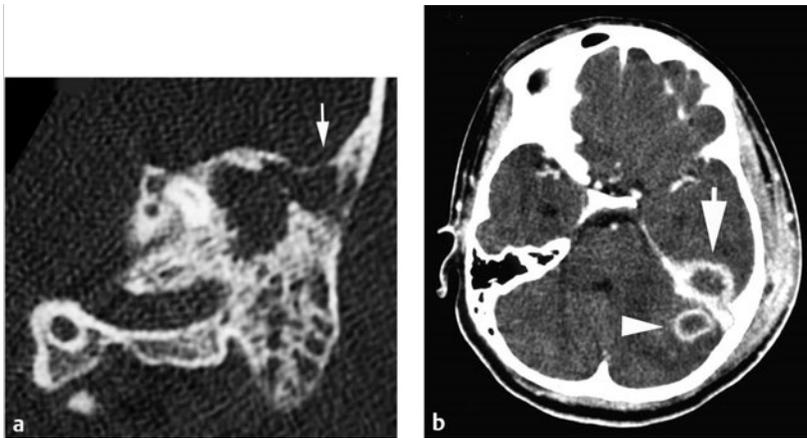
(a) Computed tomographic (CT) scan of the temporal bone of a child with otitis and mastoiditis shows opacification of the antrum and mastoid cells with erosion of the tegmen tympani (white arrow). (b) CT scan of the brain with enhancement in the same patient demonstrates a small abscess in the left cerebellar hemisphere (white arrowhead) and an extracerebral abscess on the floor of the middle fossa (white arrow). At surgery, the middle fossa collection proved to be epidural. (Courtesy of Drs. Joseph Piatt, Jennifer Smith, and Eric Faerber.)
